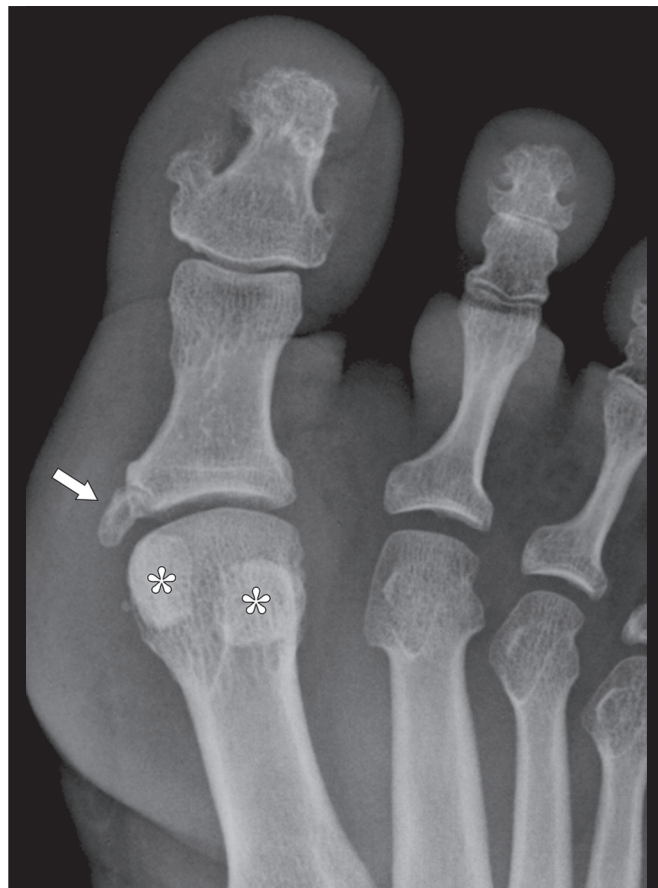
Radiograph of the hallux of a patient with acromegaly, showing a coarse, beak-like enthesophyte (arrow) at the base of the proximal phalanx, the insertion site of the medial collateral ligament of the metatarsophalangeal joint. Note also the hypertrophy of the sesamoid bones (asterisks).
